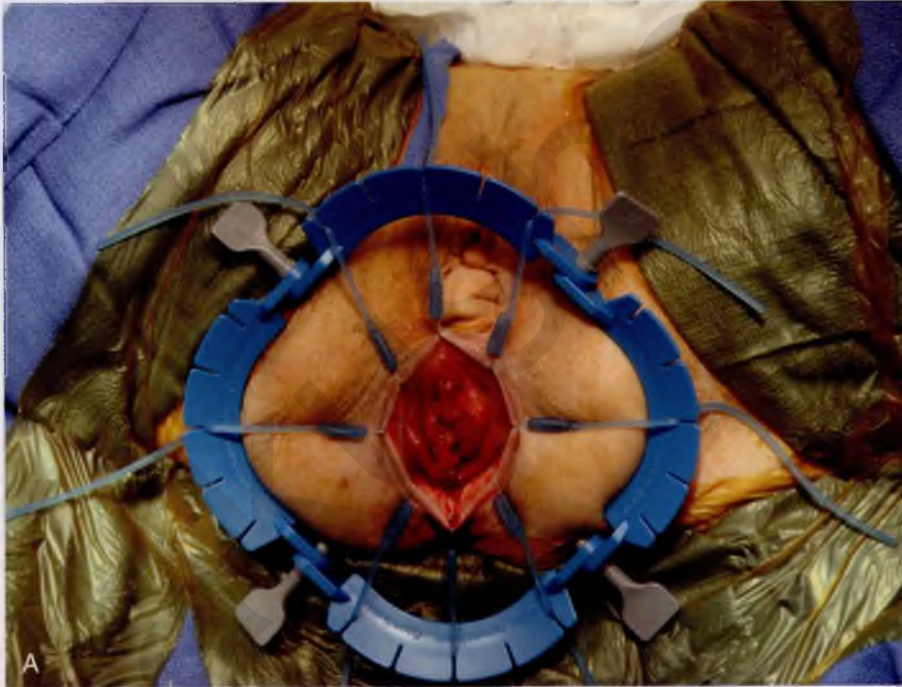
A. The Lone Star Retractor (CooperSurgical, Trumbull, CT) is useful in everting the anus while exposing the rectal mucosa and anal transition zone. The characteristic patulous anus of patients with prolapse is evident. B. The dotted line shows the point of transection.
